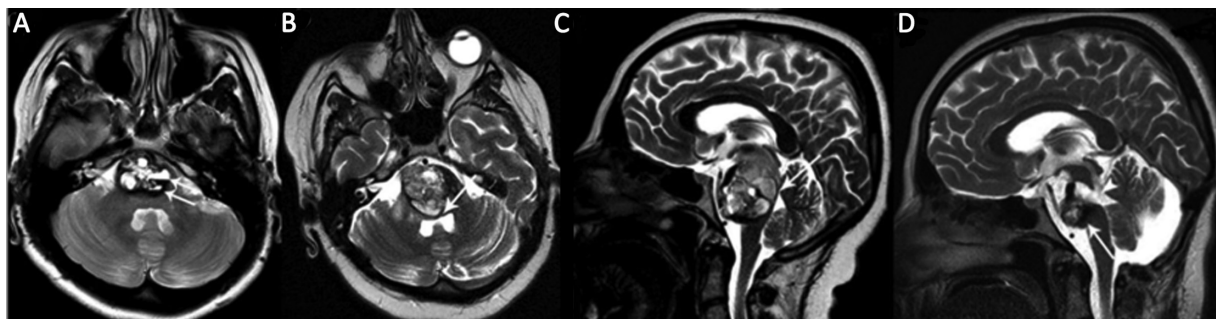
A pontine cavernous malformation (CM) in a 27-year-old female patient with headache and ataxia. (A) Axial T2-weighted magnetic resonance (MR) image shows a pontine CM with cystic components, showing hematocrit levels (arrow). (B) Axial and (C) sagittal T2-weighted MR images show a prominent progression of the lesion in the 6-month follow-up period after Gamma Knife surgery treatment, causing fourth ventricle compression (arrows). (D) Sagittal T2-weighted postoperative MR image shows partially resected CM (arrow) and postoperative porencephaly (arrowhead).
